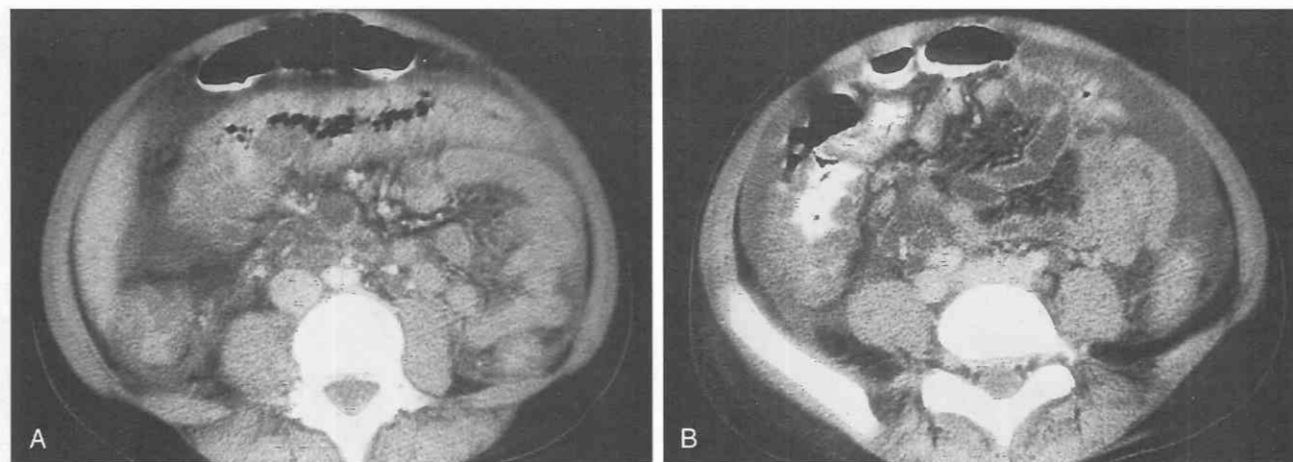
Ischemic colitis. *A*, CT scan through the midabdomen demonstrates bowel wall thickening in the transverse colon. *B*, CT scan in same patient 3 cm below *A* demonstrates bowel wall thickening involving the ascending colon. The thickened colonic wall has a diffuse, low-attenuation appearance. The patient was noted to have ischemic colitis with perforation at surgery.
